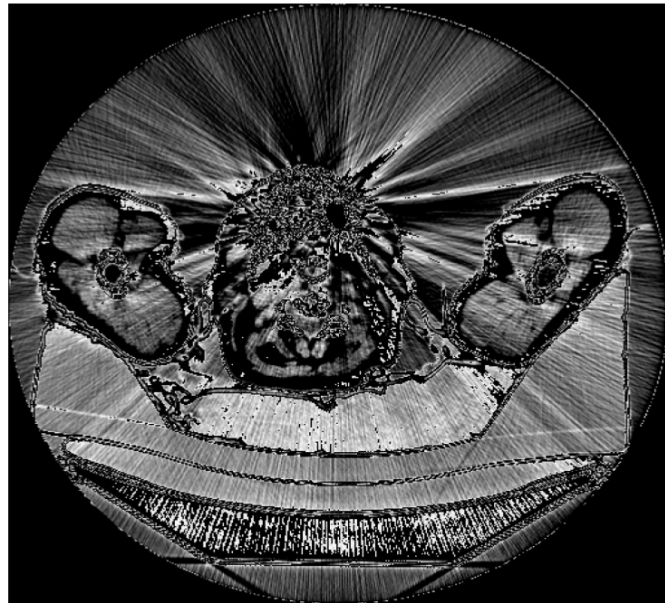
CT Image from the HNSCC Dataset
